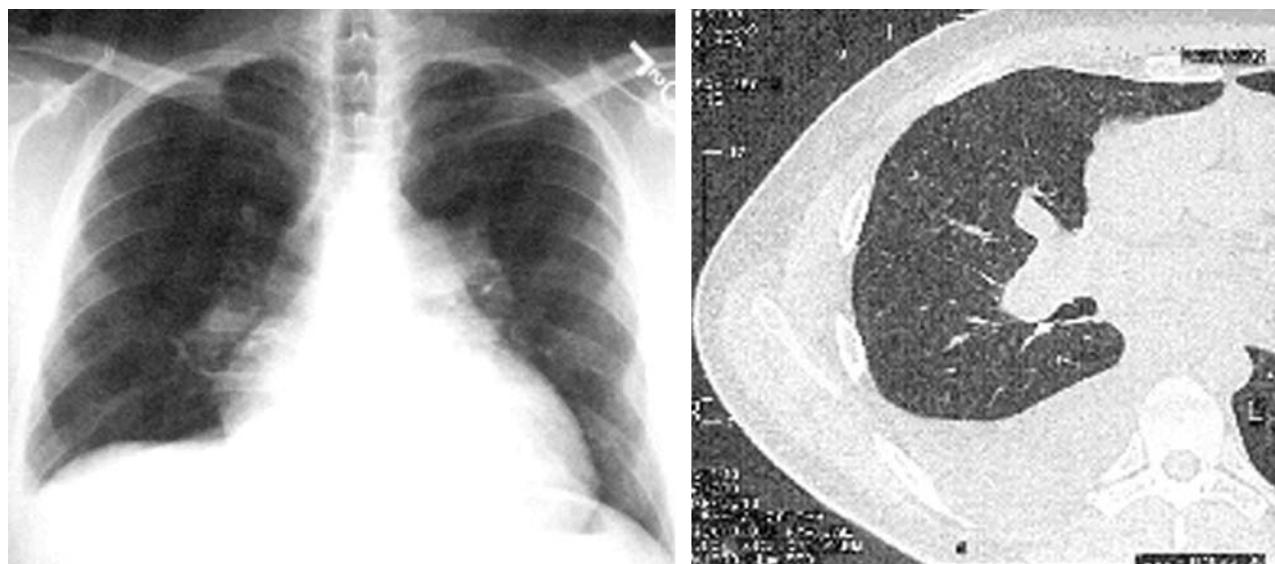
Chest radiograph (A) revealed cardiomegaly and enlarged bilateral pulmonary arteries. In (B), a high resolution CT of the chest demonstrated ground glass appearance, increased septal thickening, and diffuse fine nodules.
